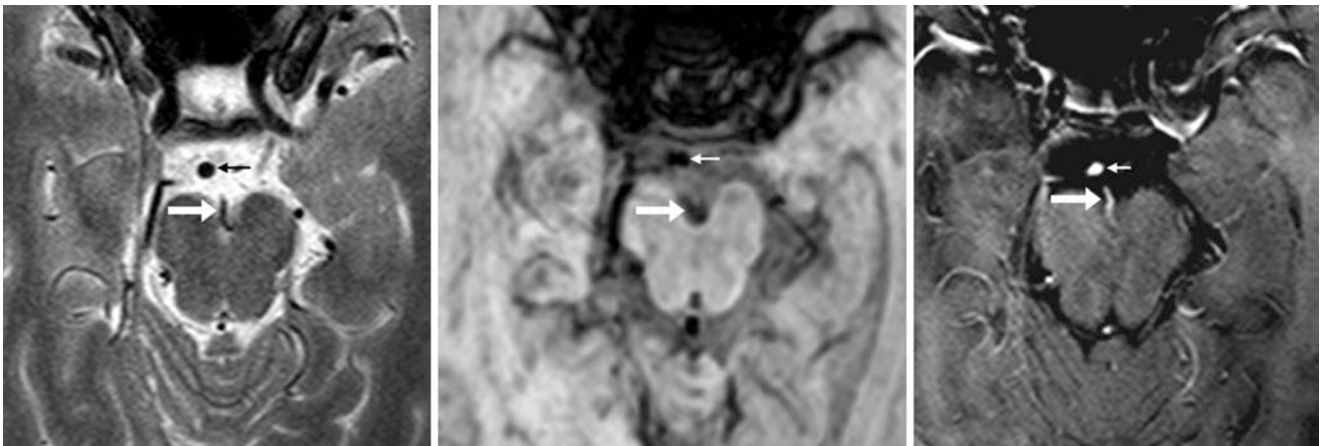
48-year-old with a linear flow void (*arrows*) on an axial T2WI MRI (*left*) within the interpeduncular fossa, situated posterior to the basilar tip (*thin arrows*). On SWI (*middle*), this flow void is only
